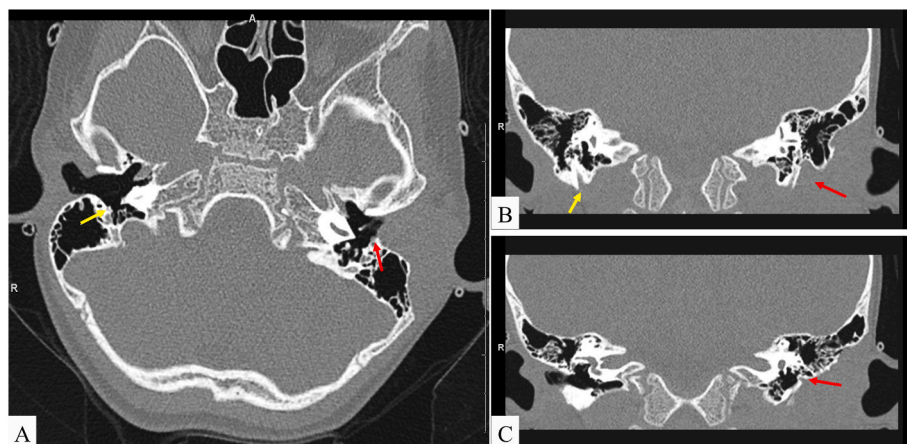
(a) Axial, and (b, c) Coronal CT demonstrating cortical bone remodeling from the lesion and its relationship to the vertical segment of the facial nerve (red arrows). Yellow arrows represent the normal contralateral side for comparison.
